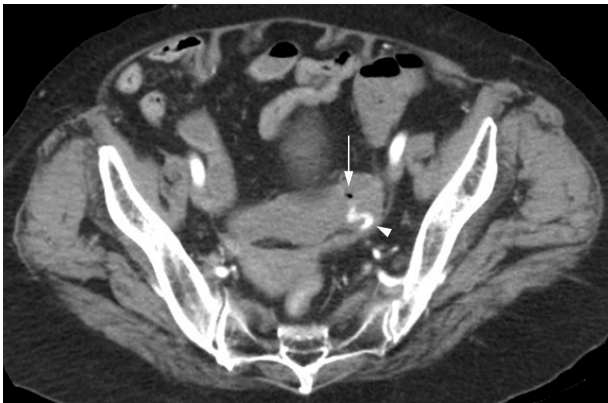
The abdominal computed tomography image showing an air bubble (arrow) and an extravasation of contrast (arrowhead) in the sigmoid colon.
